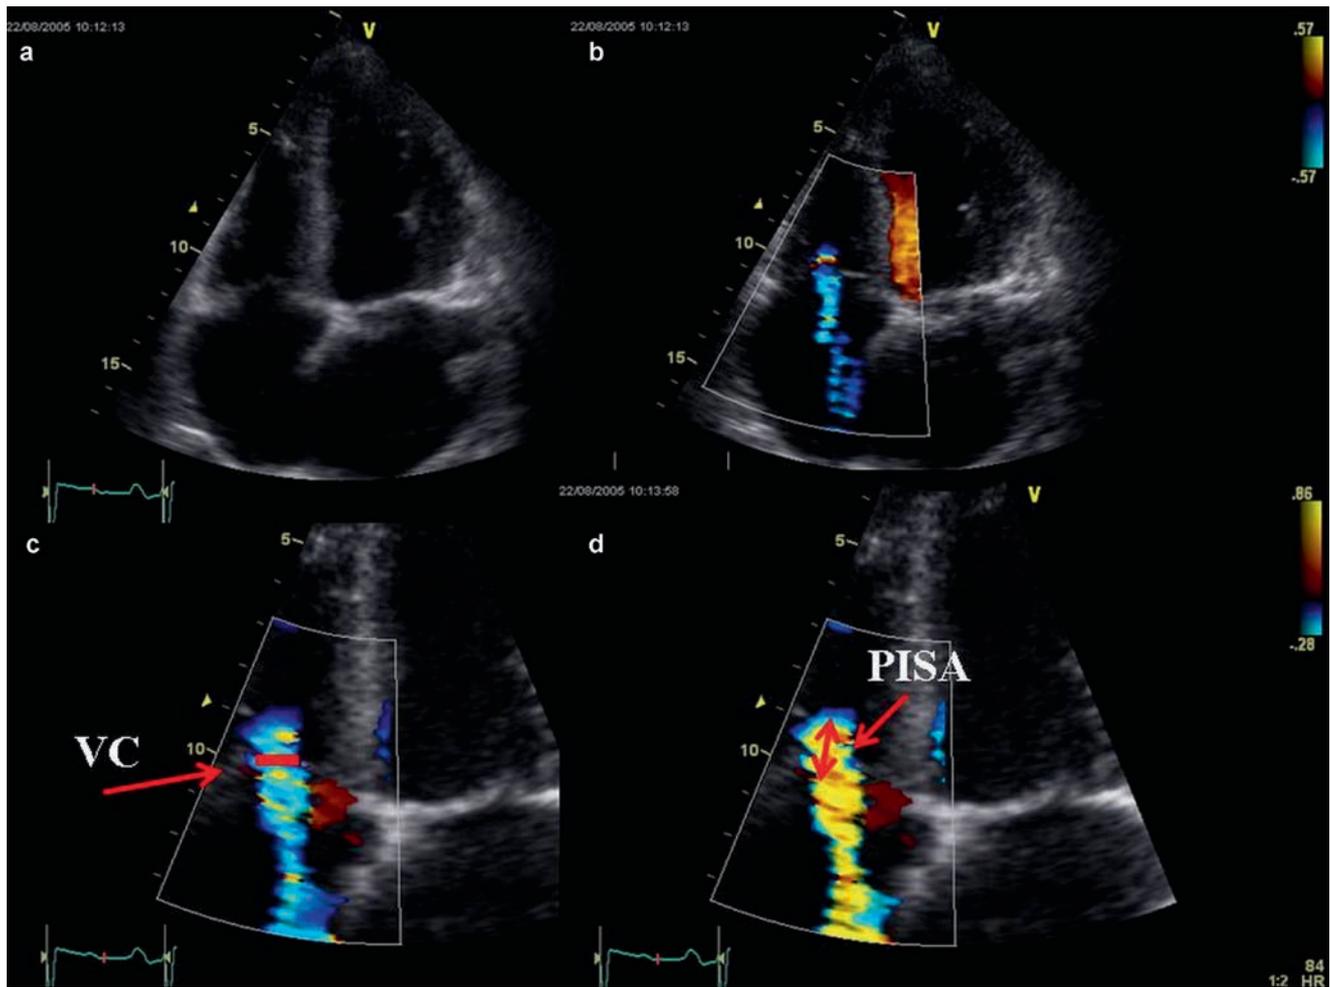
Quantitative assessment of TR severity using the VCW and the PISA method. Stepwise analysis of TR. (a) Apical 4-chamber view (AP 4-CV). (b) Colour flow display. (c) Zoom of the selected zone to
